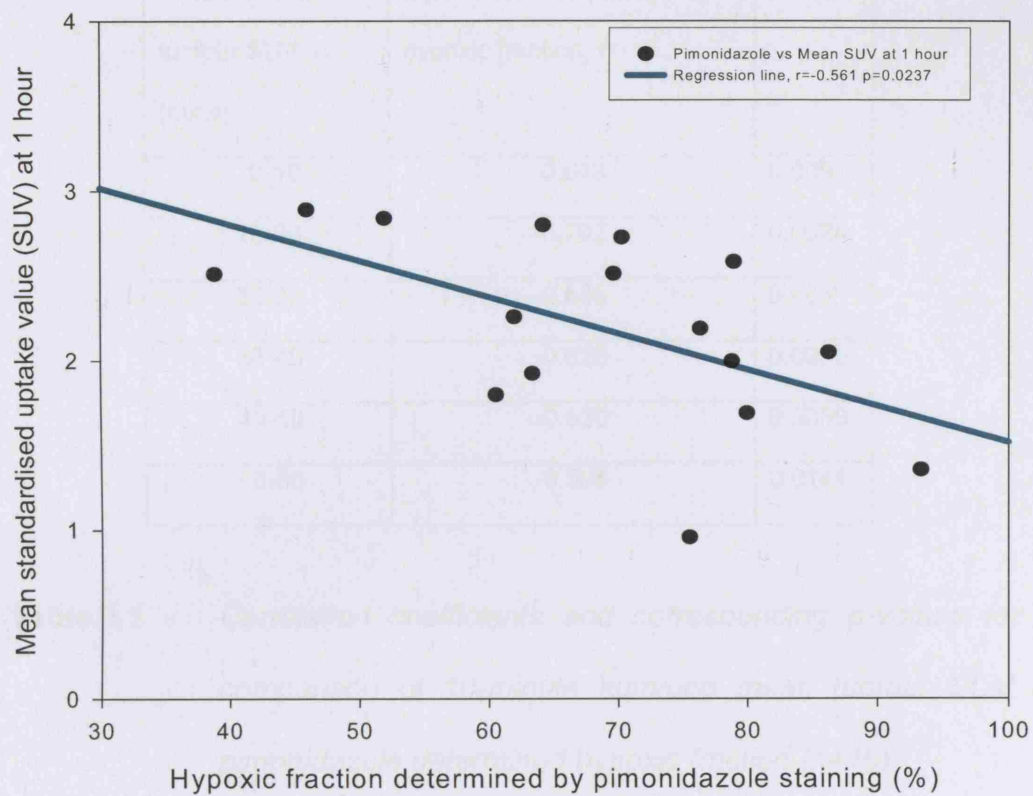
Mean tumour SUV at 1 hour versus pimonidazole determined hypoxic fraction (n=16)
